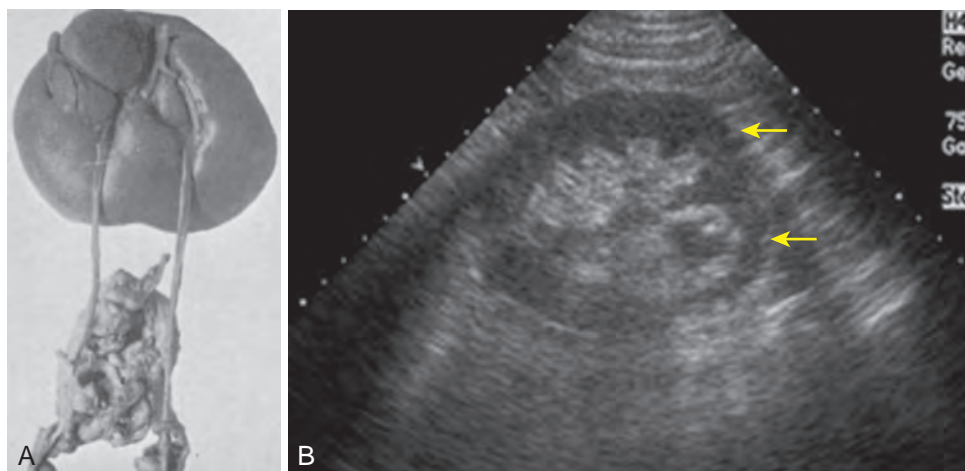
A, Lump or cake kidney showing the unusual anatomy, with the anterior blood supply coming from above and the ureters leaving from below. B, Sonogram of cake kidney in sagittal view (arrows). (A, Courtesy Dr. H. S. Altman.)
